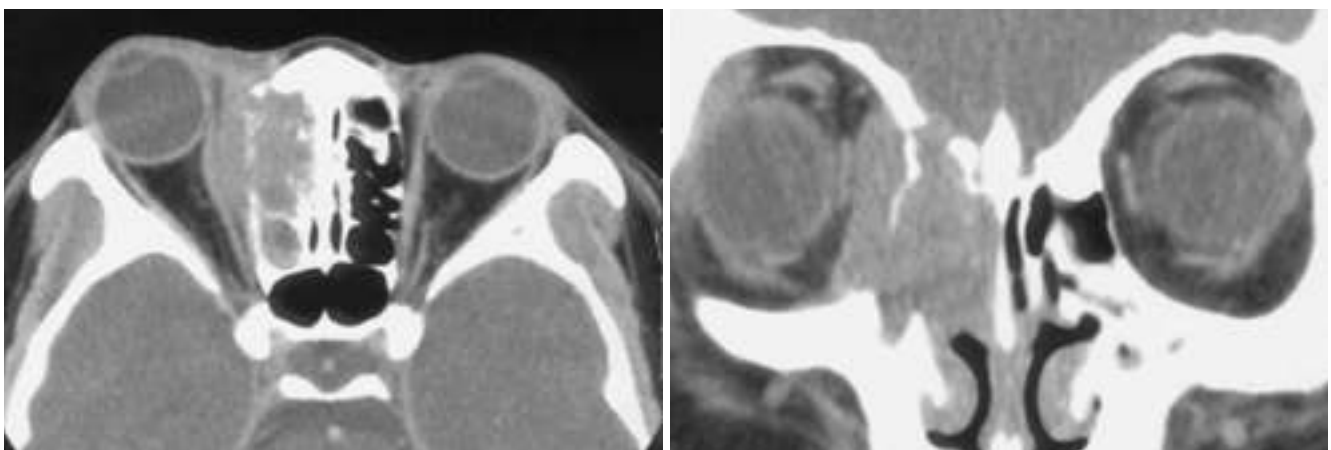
A, B. CT scan of the orbit shows moderate degree homogeneously contrast enhancing soft tissue mass in ethmoid sinus. Notice the extension of the soft tissue mass to extraconal space of orbit, nasal cavity, maxillary sinus, and intracranial space with permeative bone destruction.
